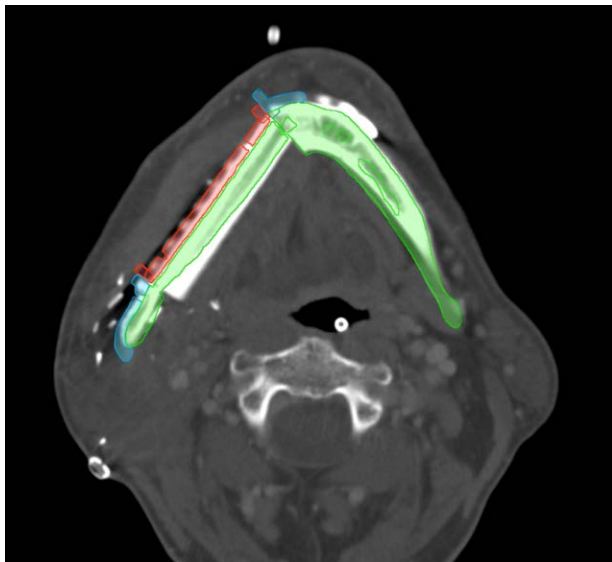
Patient A postoperative control was performed with postoperative CT and preoperative planning fusion. Mandibular reconstruction is highlighted in green, mandibular resection guide in blue, and fibula guide in red. A satisfactory overlay is achieved between the reconstruction and the preoperative objective.
